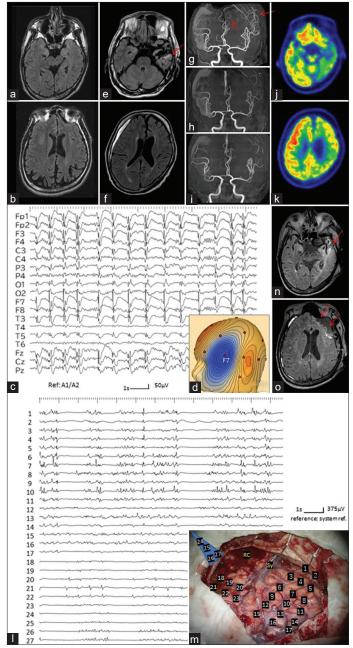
(Patient 1) (a and b) Oblique views, along with the long axis of the hippocampus, of the magnetic resonance (MR) images with fluid attenuated inversion recovery (FLAIR) sequences, before the left anterior temporal lobectomy at the age of 38, demonstrate a small size of the left calvarium and left entire hemisphere, not just the left temporal lobe. (c) Electroencephalogram (EEG) on day 1 shows lateralized periodic discharges (LPD) at the left fronto-temporal region. (d) Voltage topography of LPD indicates that the maximum amplitude of LPD is located at F7 of International EEG 10-20 system. Blue indicates negativity. (e and f) Axial views of FLAIR images on day 2 depict gliosis in the temporal lobe posterior to the resection cavity (red arrow in e). No definite abnormality is noted at the left frontal lobe (f). Thin chronic subdural hematoma, caused by a fall due to generalized seizure, is also noted on the right side. (g) MR angiography shows increased signals of the peripheries of the left middle and anterior cerebral arteries due to "ictal hyperperfusion" (red arrows). (h and i) On MR angiography of day 9 (h) and day 17 (i), the ictal hyperperfusion is improved. (j and k) Positron emission tomography with fluorodeoxyglucose on day 19 shows rather low metabolism not just in the left temporal lobe, posterior to the resection cavity, but the left entire hemisphere. (l) Intraoperative electrocorticography depicts high-amplitude periodic discharges on the frontal lobe (electrode No 1-10). Asynchronous small-amplitude paroxysms are also recorded on the temporal lobe posterior to the resection cavity (electrode No. 18-22). No paroxysmal discharges are recorded from the medial part of the temporal lobe (electrode No. 24-27). (m) The location and number of the electrodes are indicated on the operative view. Blue trapezoid electrode (No. 24-27) is placed adjoining the medial and basal aspects of the temporal lobe, as described before.[11] Sy: Sylvian veins, RC: Resection cavity at the previous craniotomy. (n and o) Oblique views of FLAIR images, immediately after the operation, showing the resection area (red arrows).
